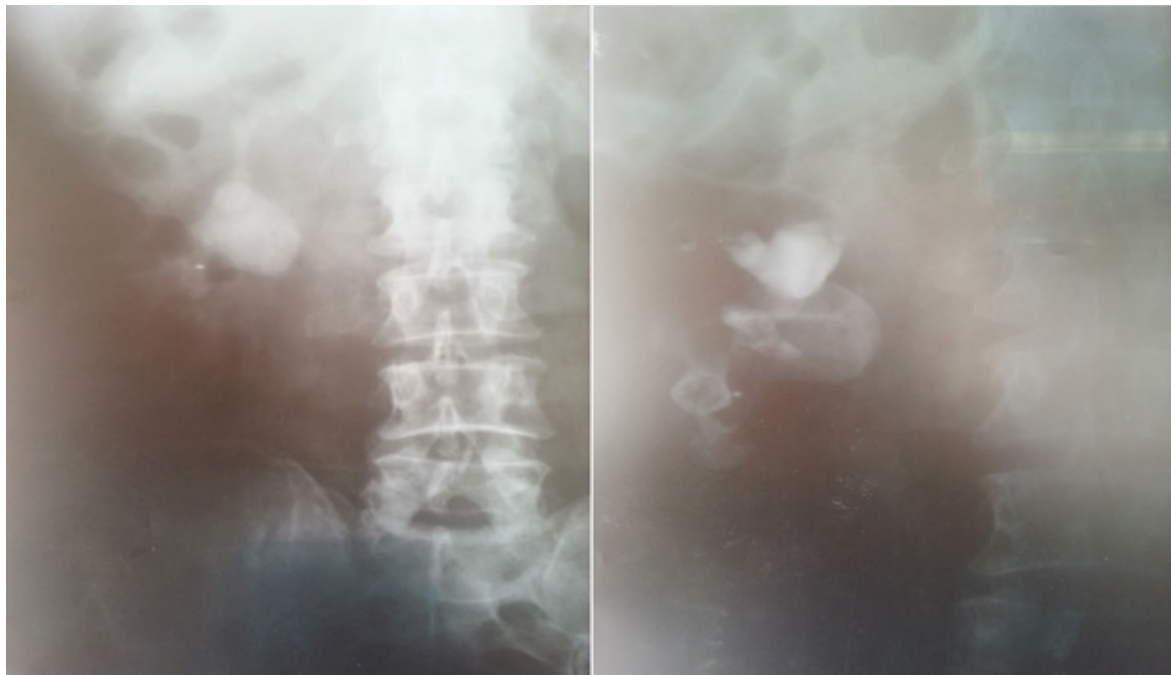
Intravenous pyelogram of the patients showing opaque stone in the left side plain X-ray, and filling defect in pyelogram in the right picture.
